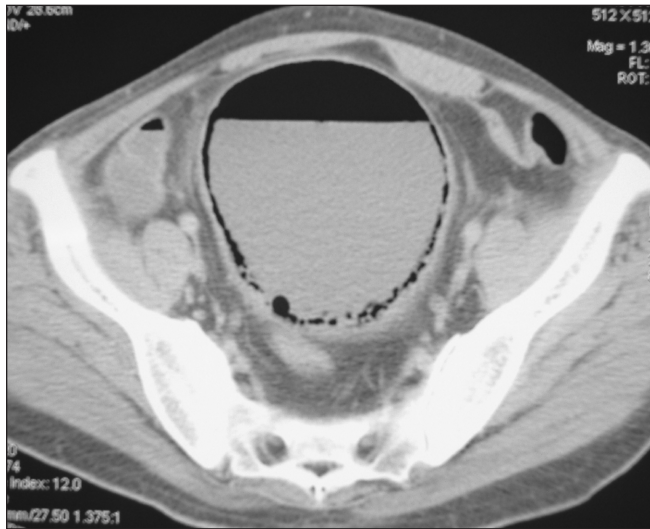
Abdominal CT scan of a 45-year-old man with septic shock.
